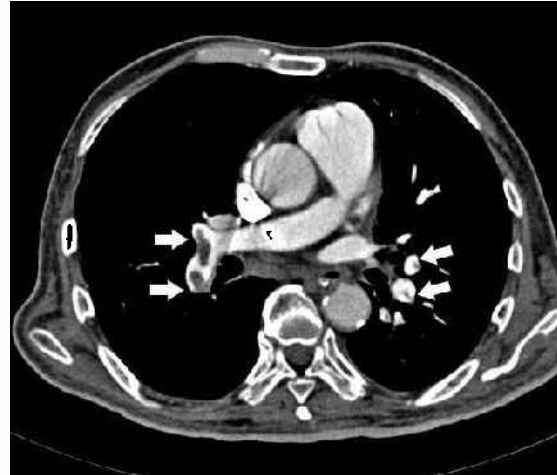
Axial CT image shows emboli at the right middle and bilateral lower lobar pulmonary arteries (arrows).
